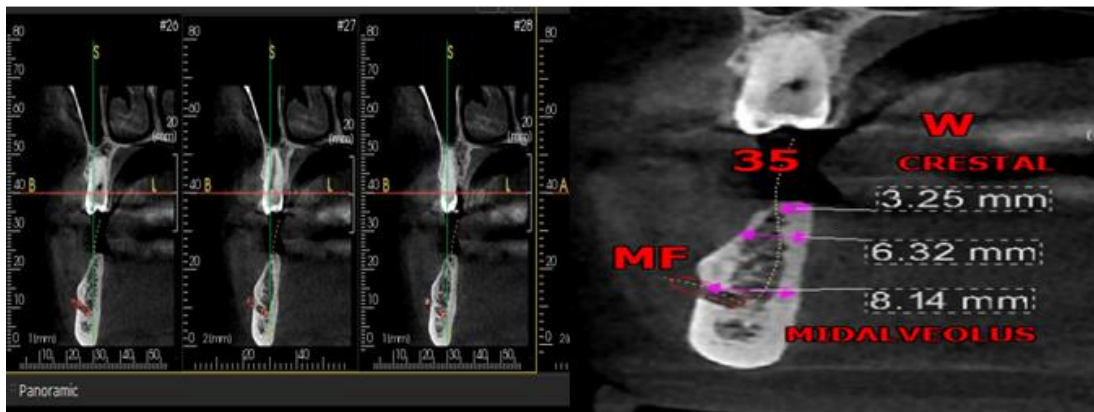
CBCT IN SECOND PREMOLAR REGION (MENTAL NERVE)
